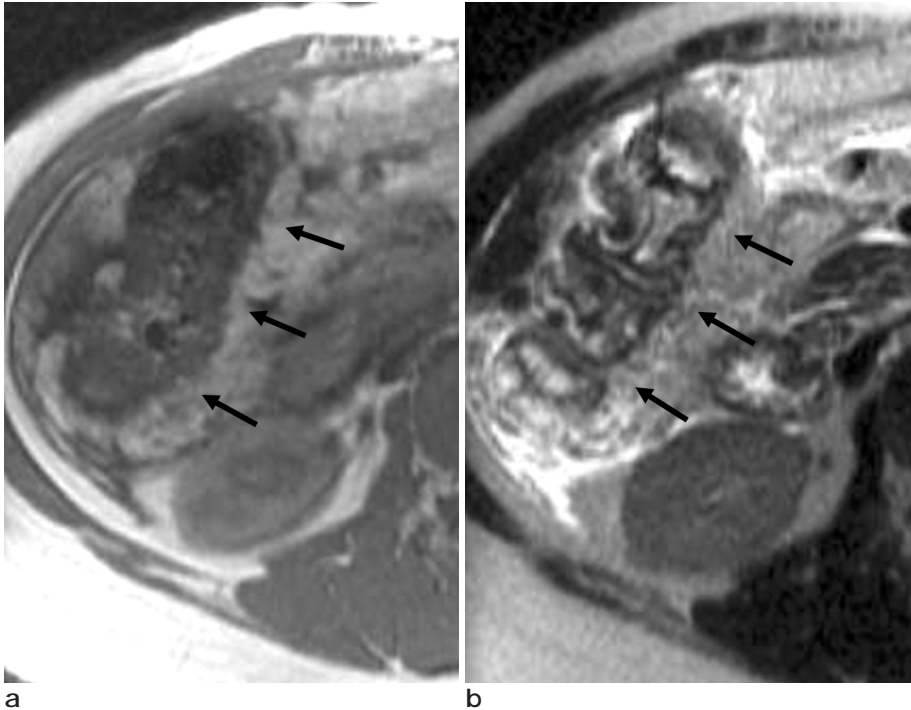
58 year-old man with minimal cirrhosis. A. T1-weighted fast spoiled gradient-echo image (180/4, 80 ° flip angle) shows mixed iso- and low signal intensity of thickened ascending colon (arrows). B. T2-weighted single-shot fast SE image (/185) shows internal high signal intensity of thickened ascending colon (arrows).
